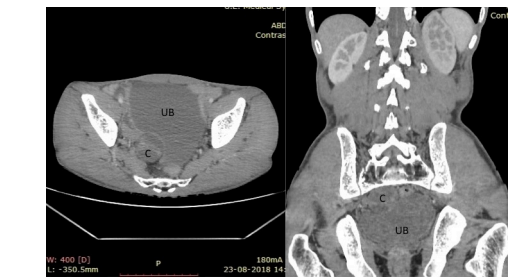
Contrast-enhanced CT showing the cyst (C) compressing the urinary bladder (UB) in transverse and coronal sections.
